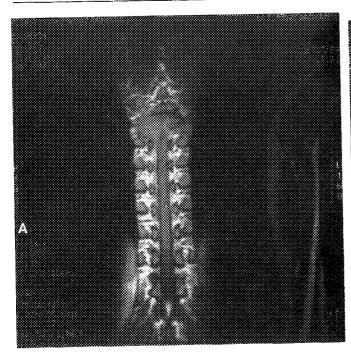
Coronal T-1 weighted magnetic resonance imaging (A) demonstrates epidural and paraspinal extension of the mass at the fifth thoracic segment. The gadolinium-enhanced axial T-1 weighted image (B) shows fibrous dysplasia involving the body, right pedicle, transverse process, and lamina with epidural and paraspinal extension.
